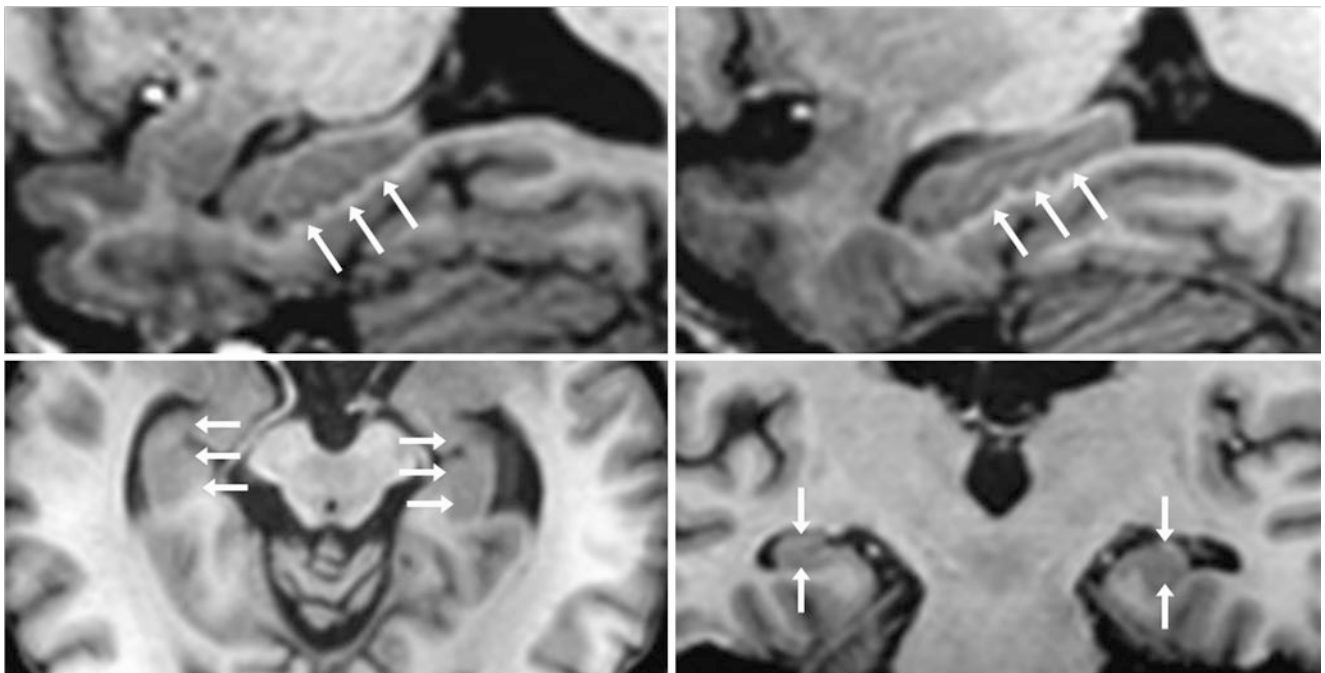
A 53 year old whose testing showed a corrugated appearance of the hippocampi bilaterally (*arrows*) on a 3 T MRI with a thin sagittal T1WI of the left (*top left*) and right (*top right*) sides. On the thin
